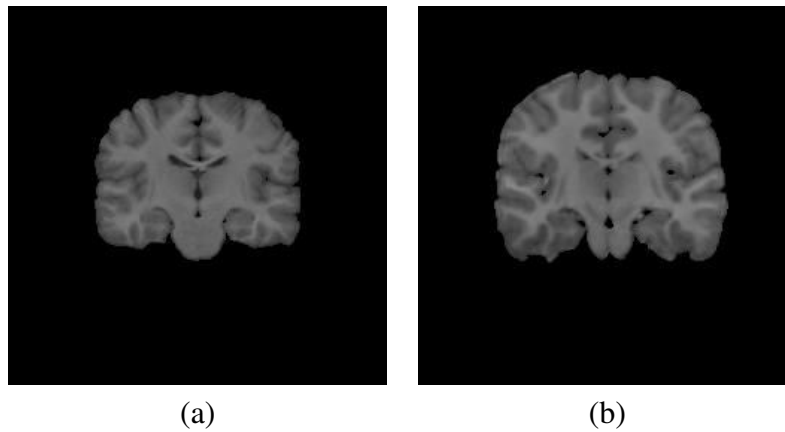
Original coronal slices of real MRI brain volumes from IBSR V2.0 collection.
